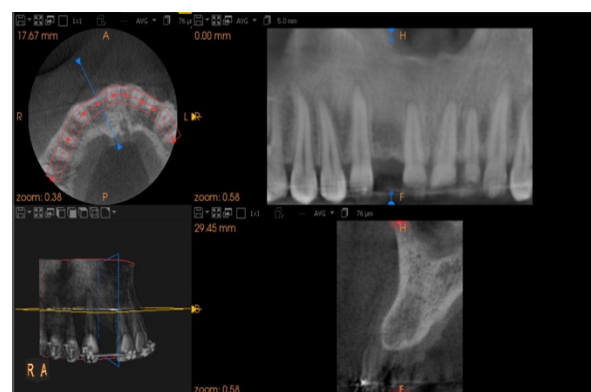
Cone Beam Computer Tomography: Different views showing the site of upper right lateral incisor.
